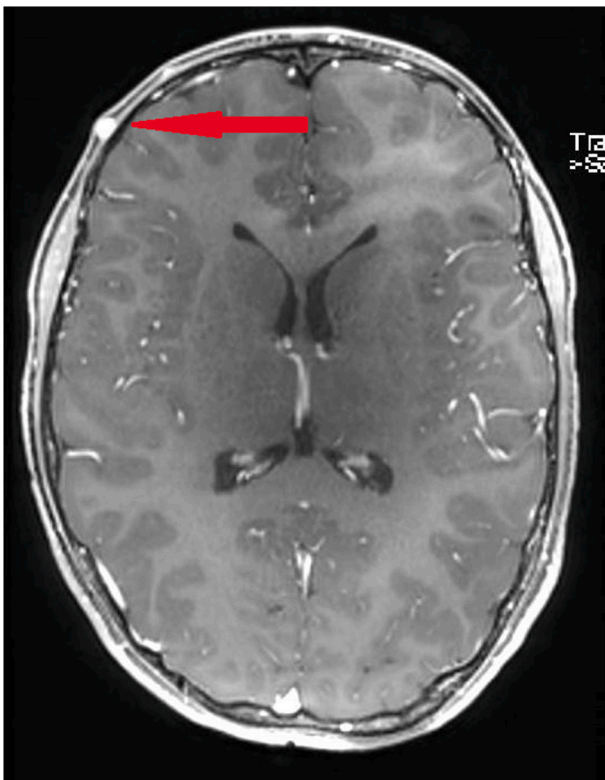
MRI showing the superficial temporal artery aneurysm.
